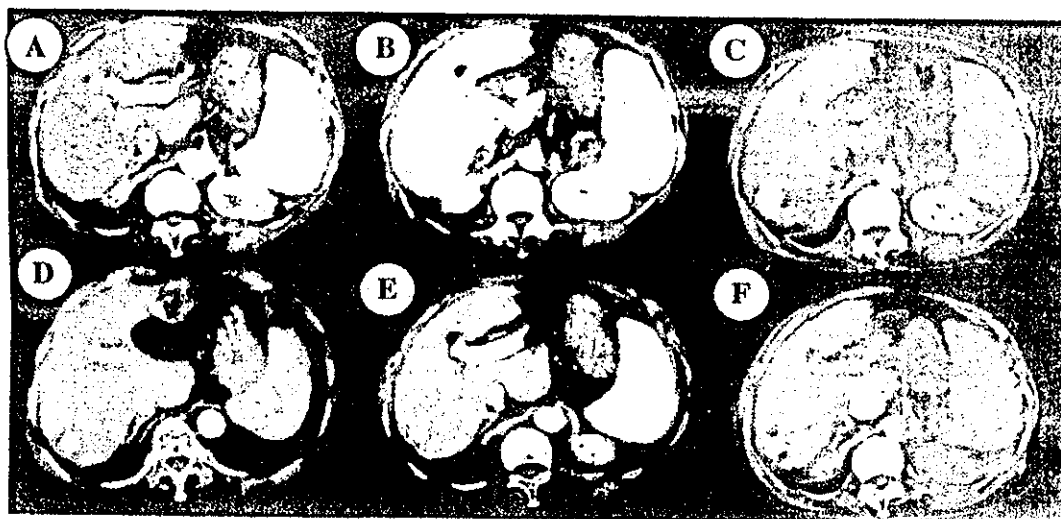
CT images of HCCs with hypo- and hyper-vascularity developed at different times in the same patient. The first HCC, 2.5 cm in diameter, was developed in the S7 region of the liver. The lesion did not show the early enhancement (A) but showed the defect (B) in the late phase of CT, indicating the hypovascularity of this tumor. After PELIT, plain CT revealed that the entire lesion was covered with lipiodol (C). Seven months after PELIT, the new lesion, 3 cm in diameter, was detected in the S1 region. The lesion showed early enhancement (D) and relatively low density (E) in the late phase of dynamic CT. After PELIT, plain CT showed that the entire tumor in the S1 region was covered with lipiodol along with the lipiodol-deposit in the S7 region (F).
